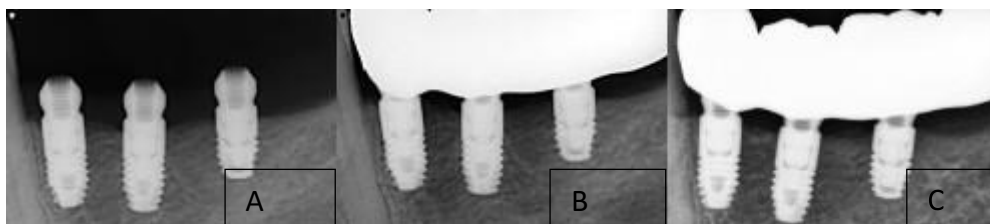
Peri-apical radiograph at T0(A), T1(B) and T2(C)
